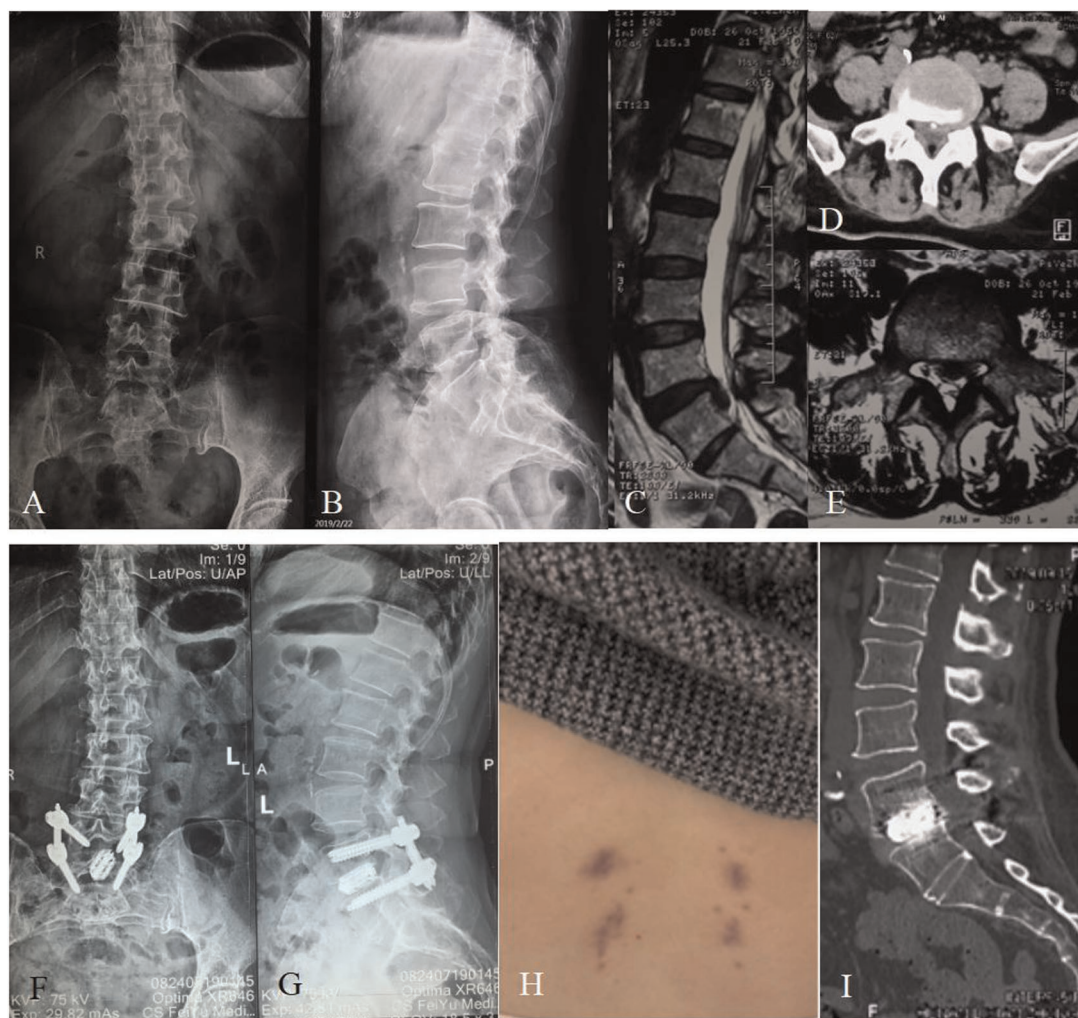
Sixty-two-year-old female with over 10-year lumbar pain and 1-week leg pain. (A,B) Preoperative X-ray showing the patient had a slightly degenerative lumbar scoliosis and had no lumbar spondylolisthesis or apparent lumbar instability. (C) Preoperative sagittal MRI showing the patient had an L5/S1 disc herniation with downward prolapse. (D,E) Preoperative cross-sectional CT and MRI showing that the herniated disc with calcification oppressed the left nerve root of S1. (F,G) The postoperative X-ray showing that the cage and pedicle screws were complete and in position. (H) There was a very small incision scar that healed well at the follow-up of 3 months after surgery. (I) The postoperative CT showing a sign of probable fusion within the interbody of L5/S1 at the follow-up of 6 months after surgery.
